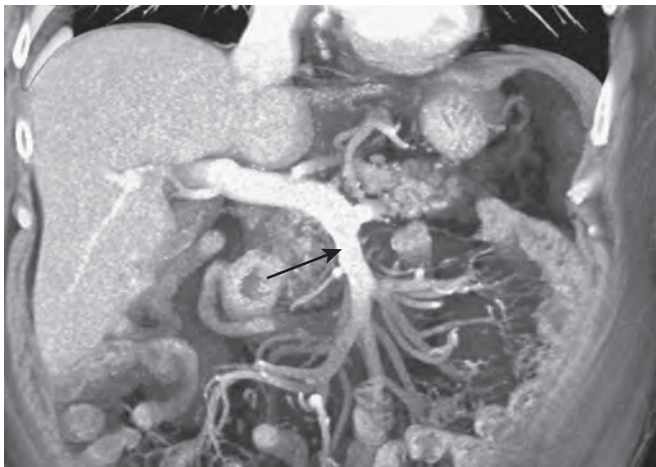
Coronal volume-rendered CT image in the venous phase. This demonstrates the normal appearance of the superior mesenteric vein (arrow) and its branches as they join the splenic vein and portal vein at the confluence.
